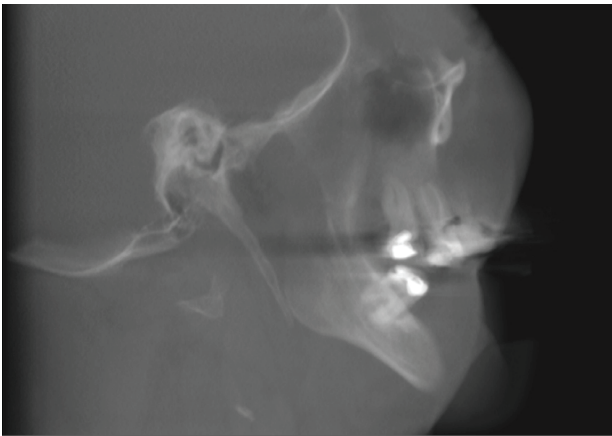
Sagittal section of the cone beam computed tomography showing the calcification of the styloid process.
